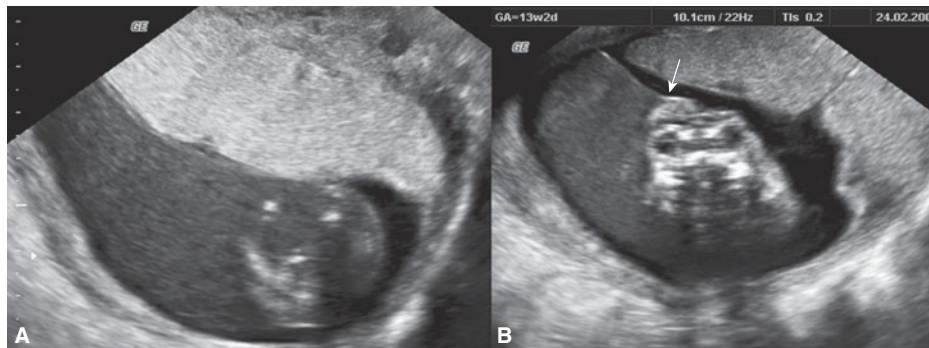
Transvaginal sonography at 13 weeks, 2 days in an anencephalic fetus. (A) “Milky” amniotic fluid. (B) Anencephaly, most probably due to amniotic band sequence. Note the continuity between the amnion and the brain remnants (arrow). (Courtesy of Gustavo Malingier.)
